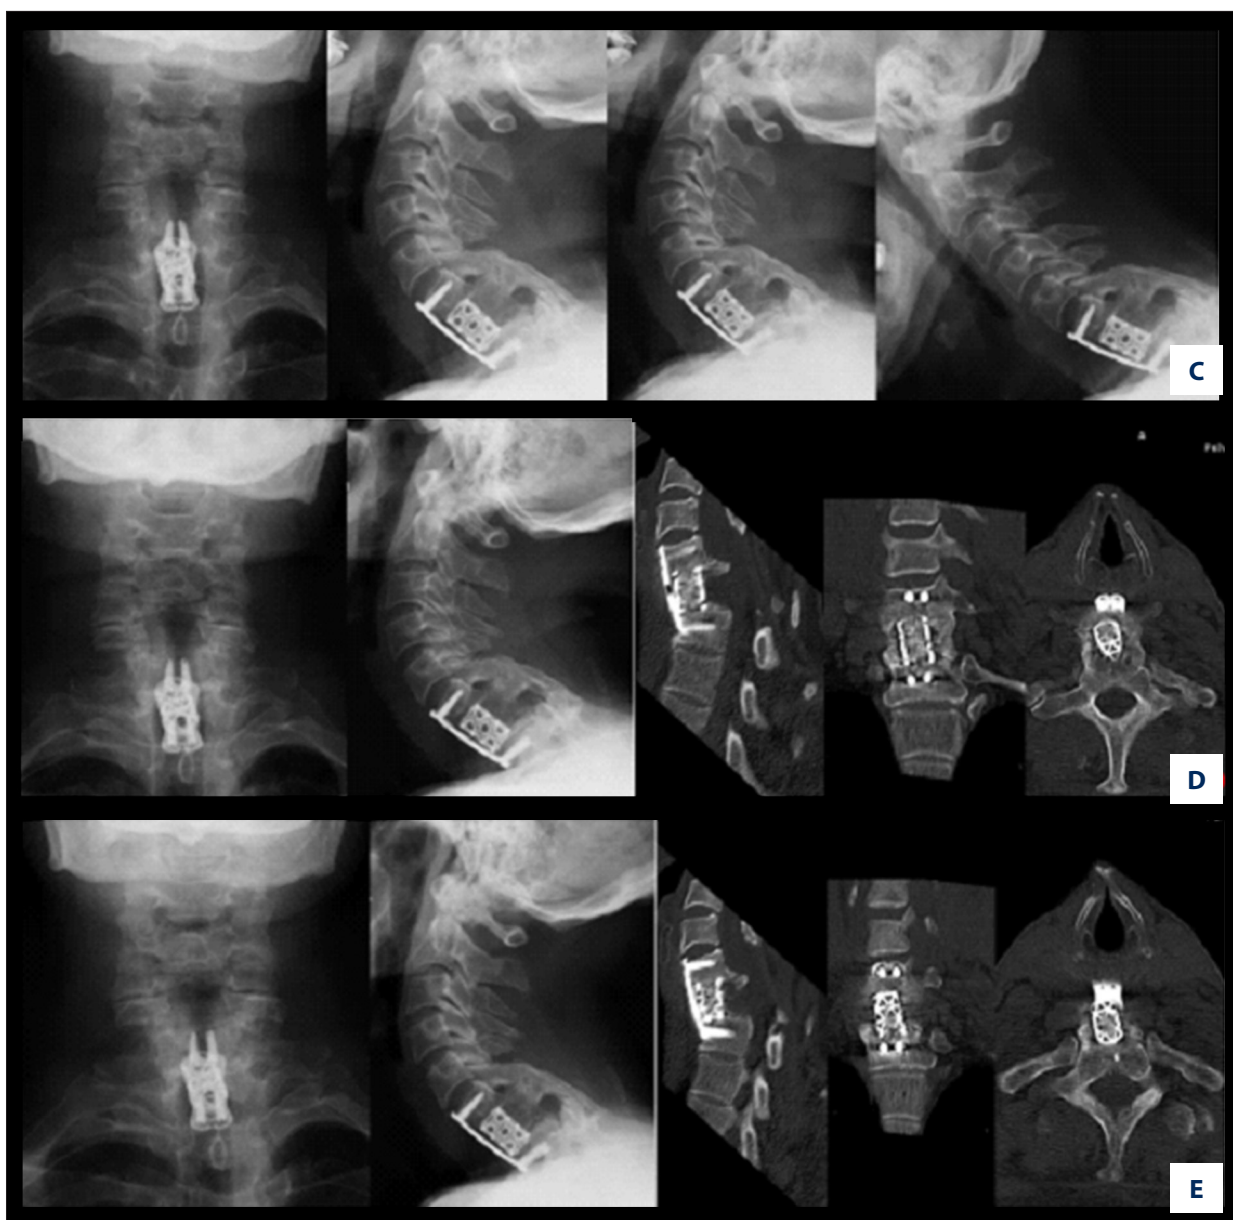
Typical case imaging data of a 62-year-old man who had a traffic accident. The C6–C7 dislocation was discovered 3 months after injury. A1–A4 indicates the patient's anteroposterior and lateral position as well as the hyperextension and flexion X-ray images. CT images (A5, A6) showing the C6-7 old dislocation with unilateral locked facet, and the MRI images (A7, A8) indicate contracture of scar tissue, prominent intervertebral discs, and signal changes in the spinal cord. B1–B4 indicates the X-ray and CT scans images postoperative, and indicates that satisfactory restoration of the dislocation was achieved. C–E show the imaging data 3 months after surgery, 1 year after surgery, and at last follow-up. Images show that interbody fusion has been completed, and surgery can effectively restore the cervical sequence and physiological curvature, obtaining permanent stability.
